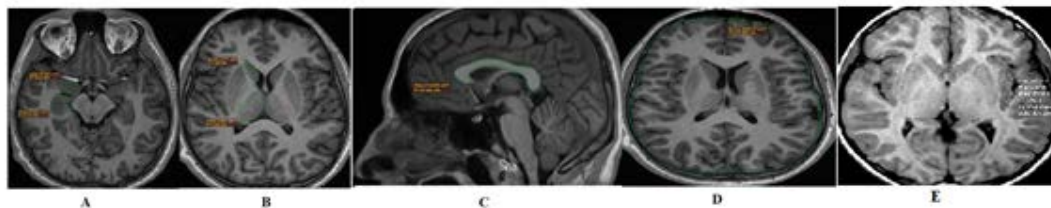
The different brain region's Magnetic Resonance Imaging. A. Amygdaloid complex and hippocampus head area measurement in patients with epilepsy in the axial plane, B. Measurement of caudate nucleus caput and thalamus area in patients with epilepsy in the axial plane, C. Corpus callosum area measurement in patients with epilepsy in the sagittal plane, D. Measurement of the largest area of the brain in patients with epilepsy in the axial plane, E. Measurement of the insula in the axial plane..
